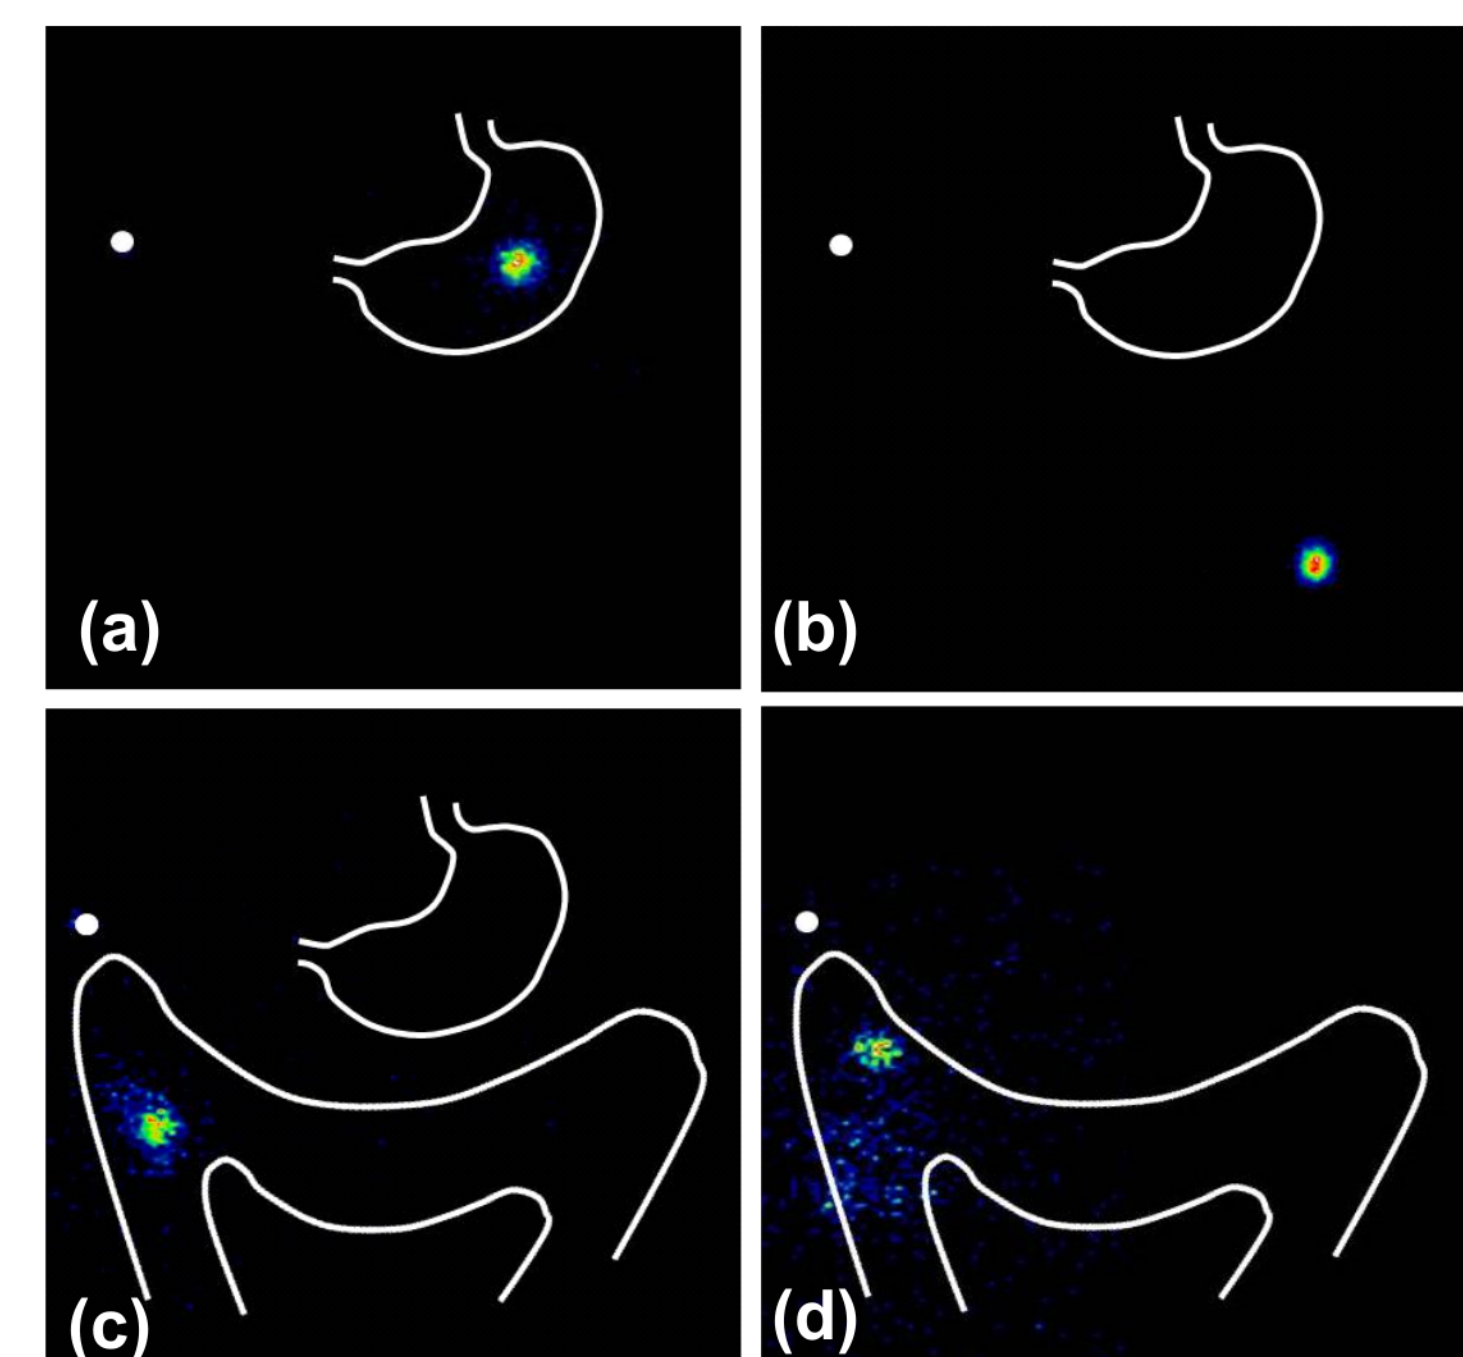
Anterior scintigraphic images of key events in the GI transit of the IntelliCap[®] capsule in Subject 003 at various times post-dose:
